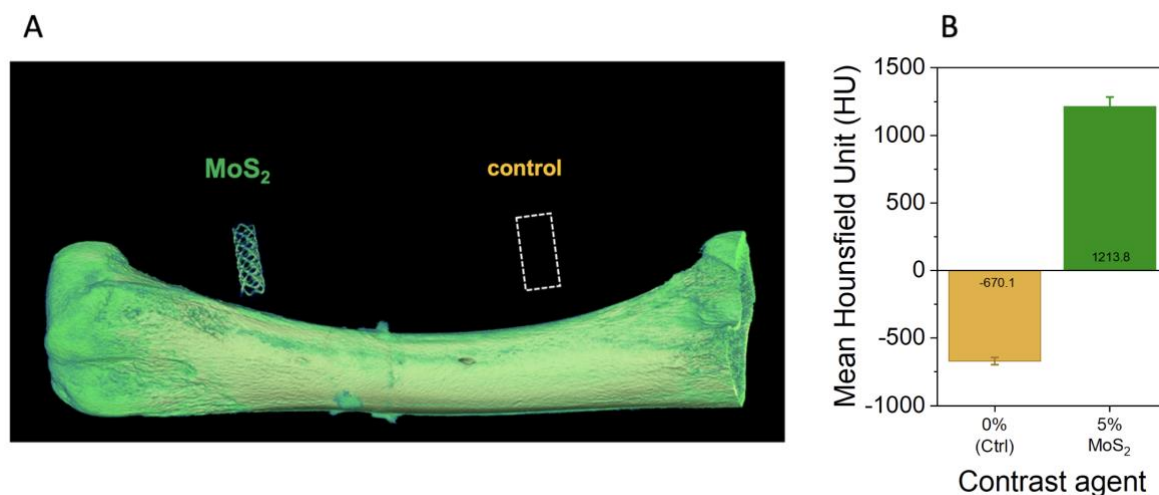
X-ray characterization of mPDC-MoS₂ STENT via computed tomography (CT). A) CT images (in muscle tissue) of control (mPDC), and MoS₂ enriched BVS. B) Mean Hounsfield values for the control (mPDC), and MoS₂ enriched BVS.
